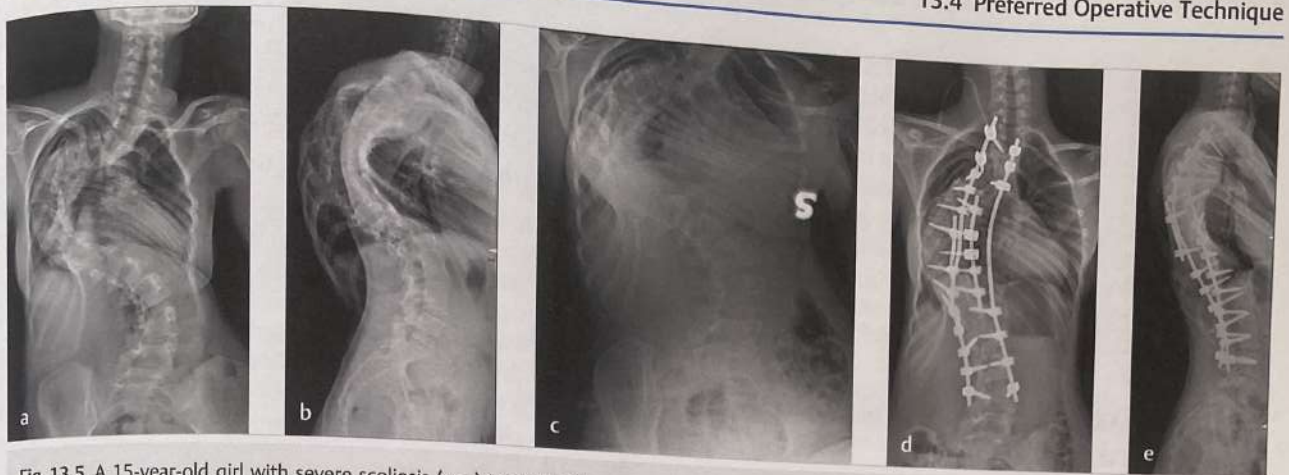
A 15-year-old girl with severe scoliosis (a–c) treated with preoperative halo-traction: (X-ray after 21 days of traction). (d, e) Treatment consisted in a posterior instrumented fusion with aggressive posterior release and thoracoplasty.
